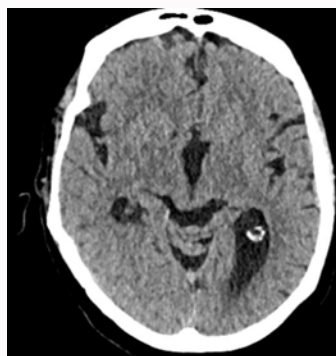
Plain CT Head: Did not show any areas of established ischemia.
